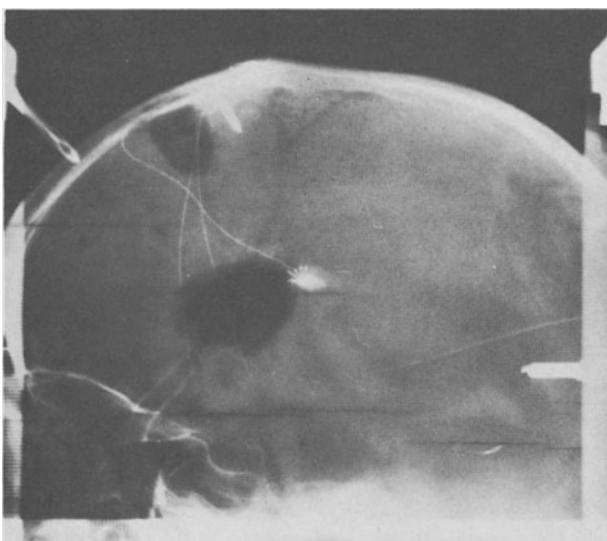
Lateral X-ray view taken during surgery showing the multilead electrodes in place
